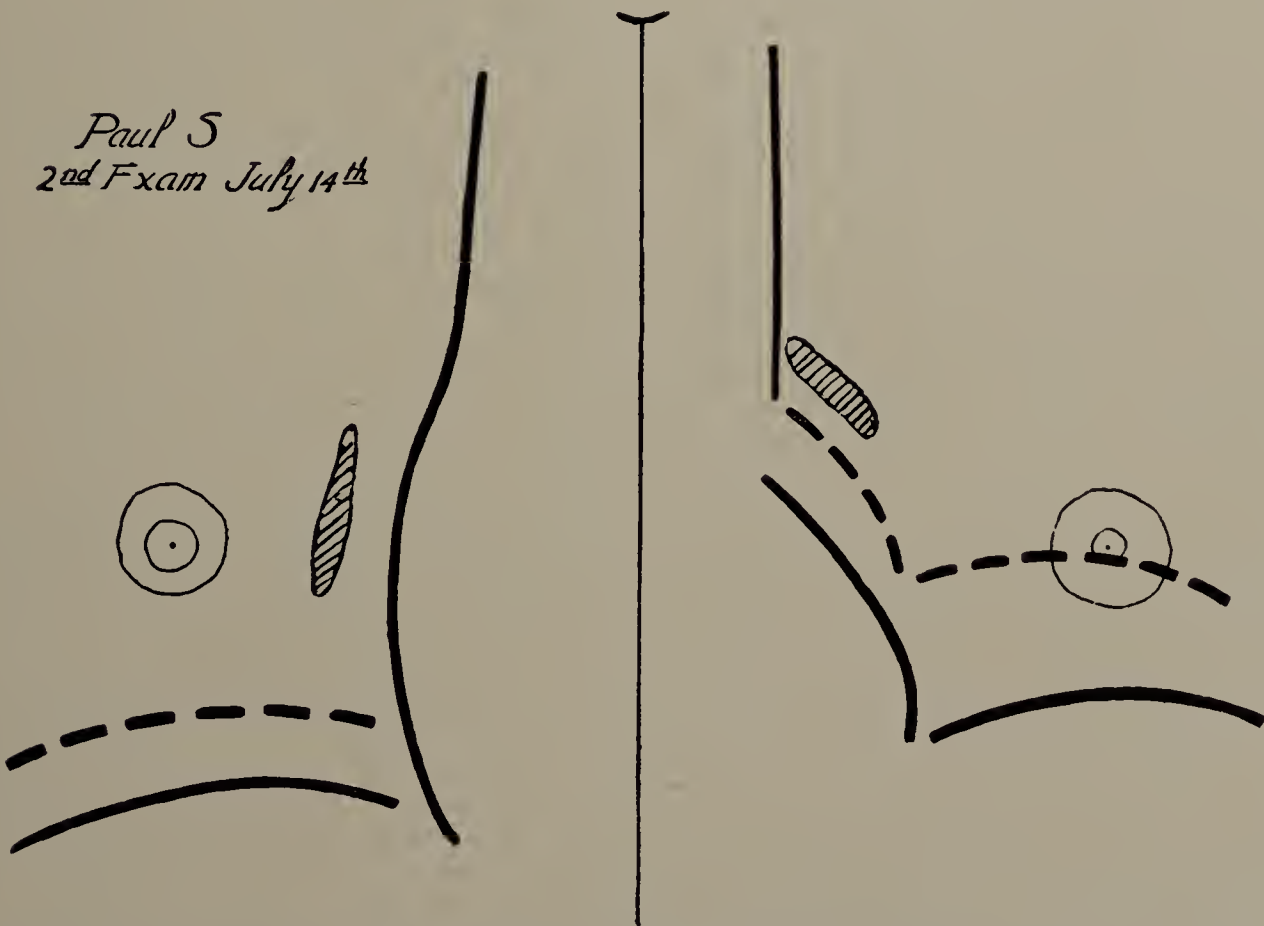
Paul S. July 14. Cut of tracing from second X-ray examination. (Cut one-third life size.)
